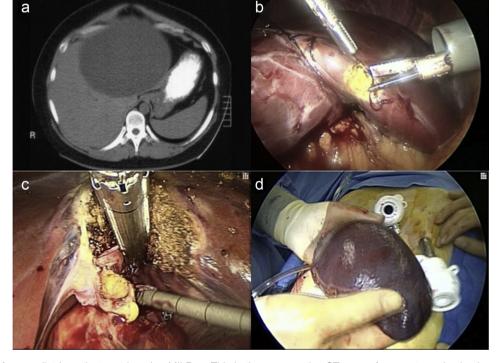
Imaging from pediatric patients undergoing MILR. a. This is the preoperative CT scan of a symptomatic simple cyst in an 8 year old patient who will undergo pure laparoscopic MILR. b. This picture was taken during pure laparoscopic resection of a 5 cm lesion of segments 5 and 6. c. This image shows stapler division of the portal triad during a laparoscopic left lateral sectionectomy for hepatoblastoma after neoadjuvant chemotherapy. d. This image shows the left lobe of the liver following laparoscopic resection in a 12 year old patient
